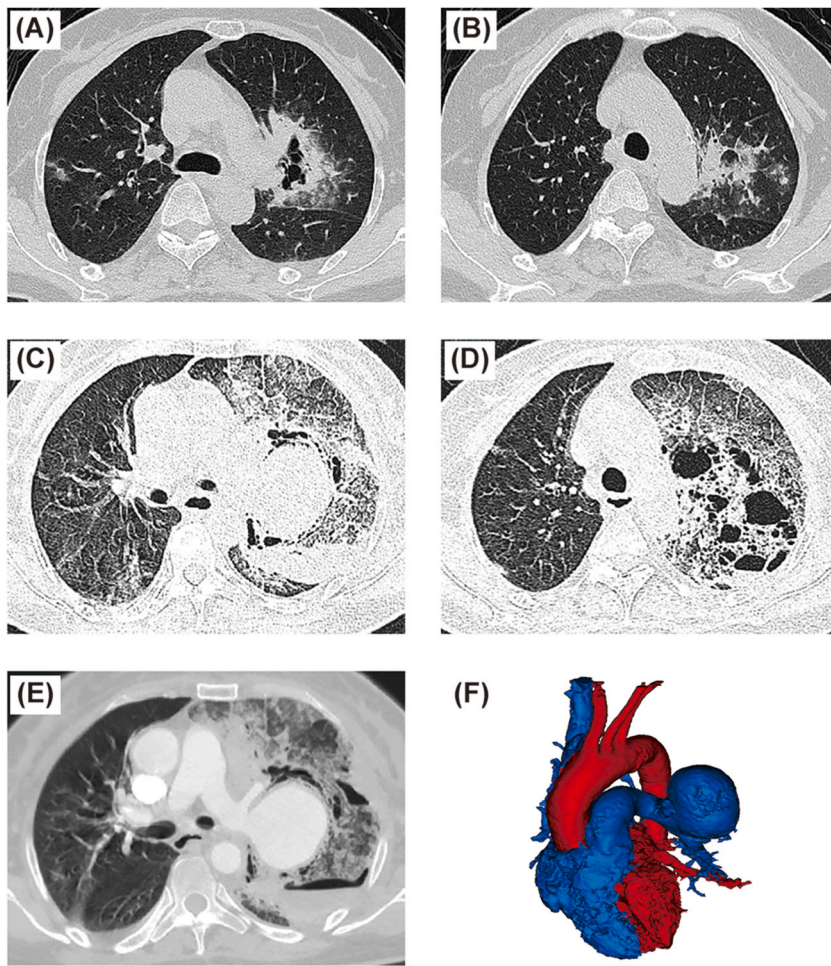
computed tomography (CT) scans. (A, B) Initial chest CT images revealed bilateral pulmonary infection and regional multiple bullae, especially around the left pulmonary hilum. (C, D) A second chest CT demonstrated worsening of the left pulmonary infection, regional multiple bullae, pleural effusion on the left side and a left hilar mass. (E, F) Contrast-enhanced CT and three-dimensional reconstruction revealed an unexpected massive aneurysm of 5.6×4.9 cm in size at the left pulmonary hilar.
